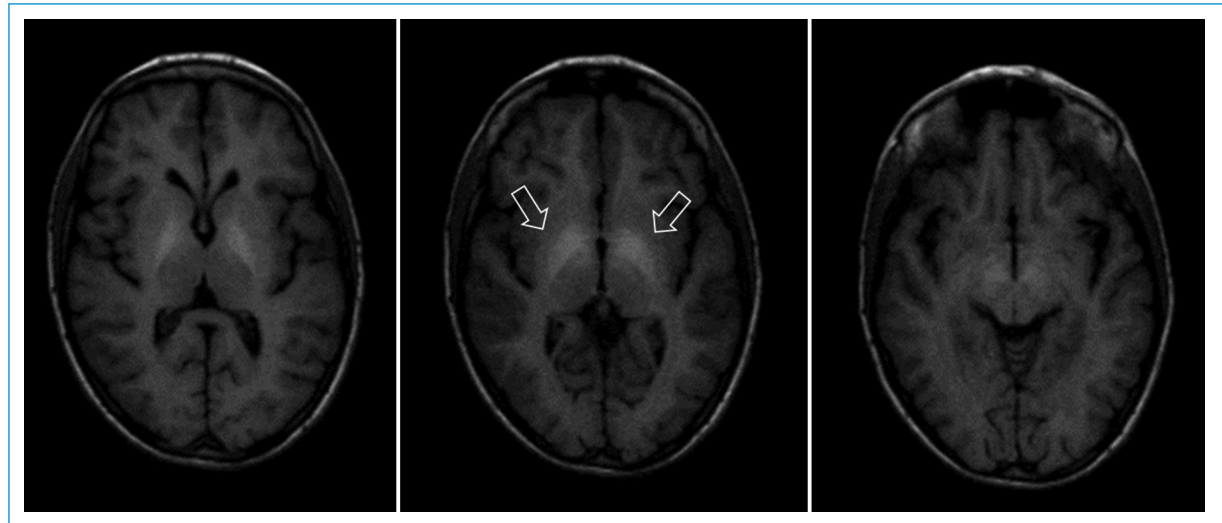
Cerebral MRI depicting bilateral basal ganglia hyperintensity (white arrows) in T1-weighted image as a result of manganese deposition in a child with long term parenteral nutrition.
